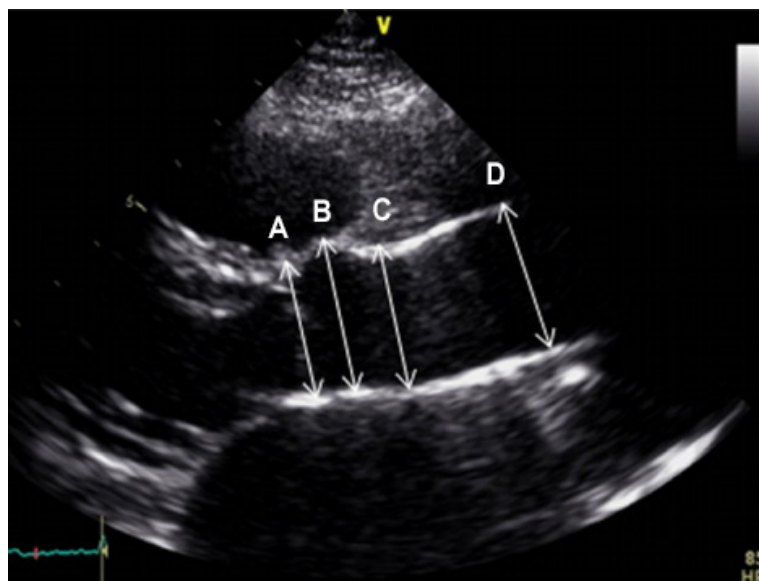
Measurements of the aorta. Two-dimensional echocardiogram of the neo-aorta, parasternal view of the long axis of the left ventricle. The measurement sites are shown: A- aortic annulus; B- sinus of Valsalva; C- sinotubular region; D- ascending aorta.
